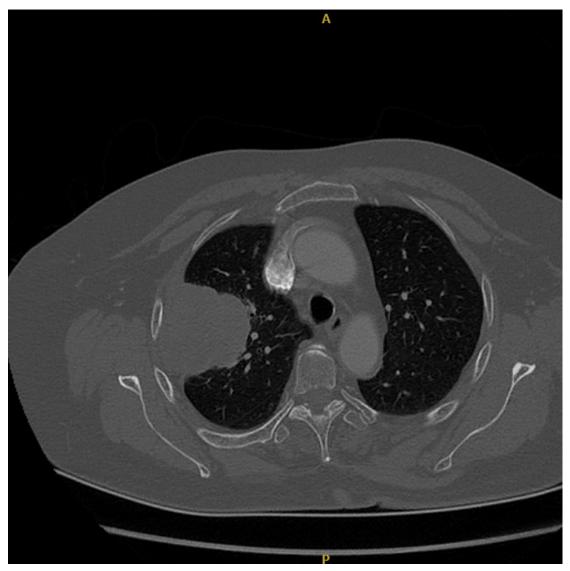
Enhanced CT revealed no discernible rib involvement
